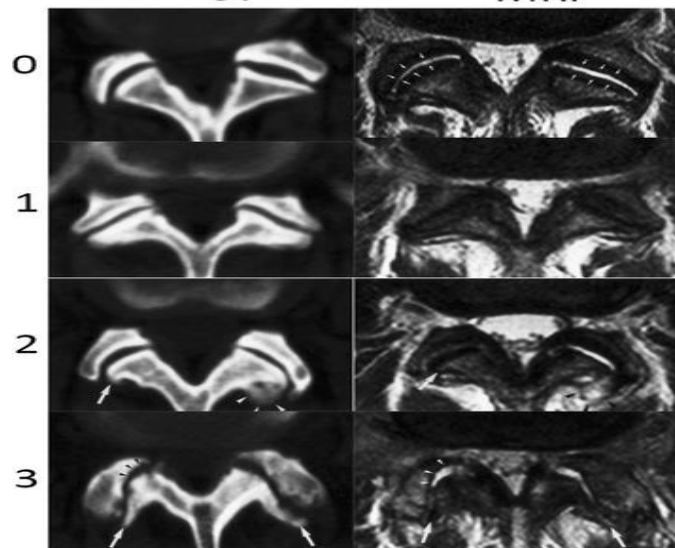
The Weishaupt grade of CT and MRI images of the lumbar facet joint [doi:10.1007/s002560050503]
